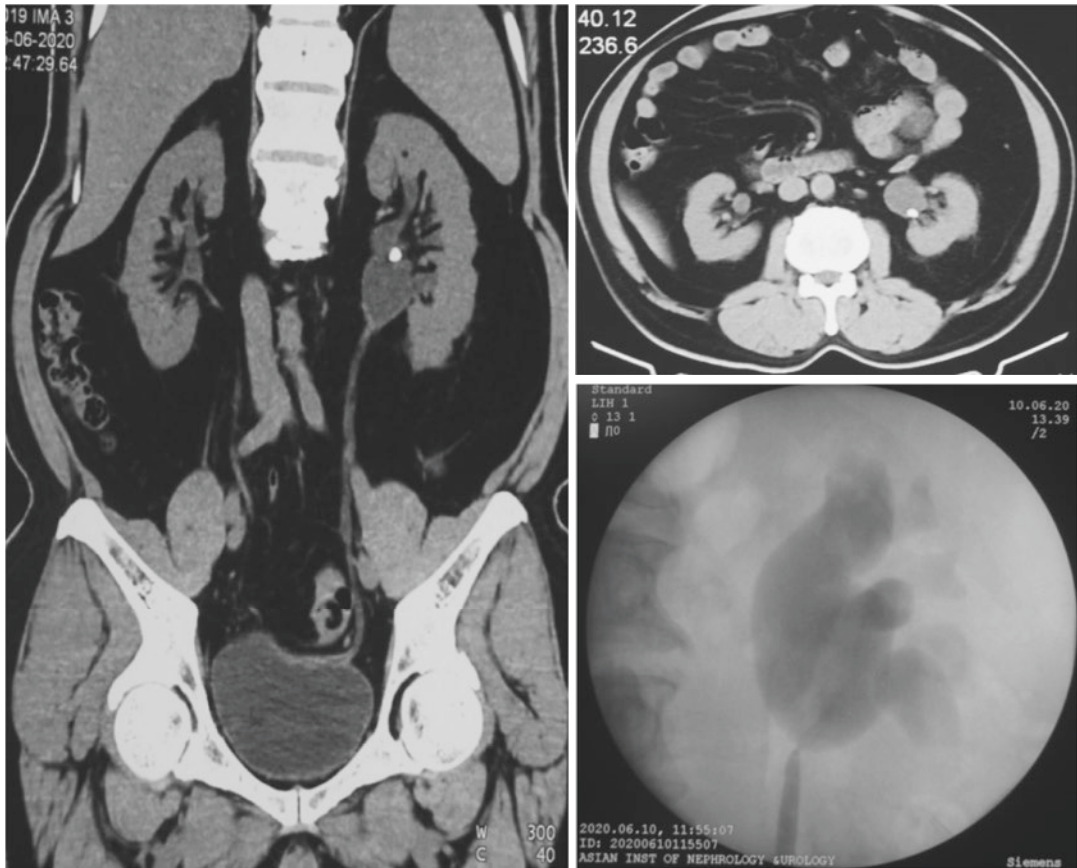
Plain CT KUB and RGP showing left renal calculi apparently secondary to suspected left PUJO
